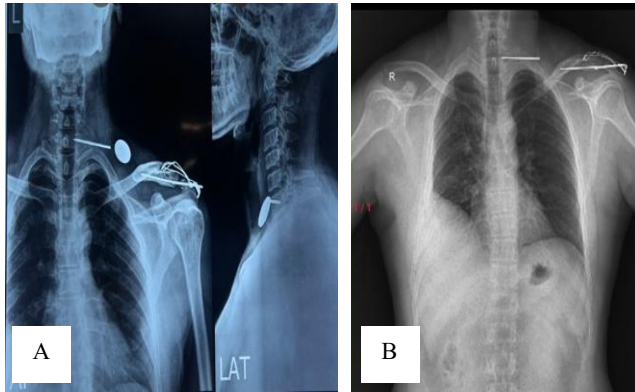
(A and B): X-ray neck AP/lateral view and chest AP view.
